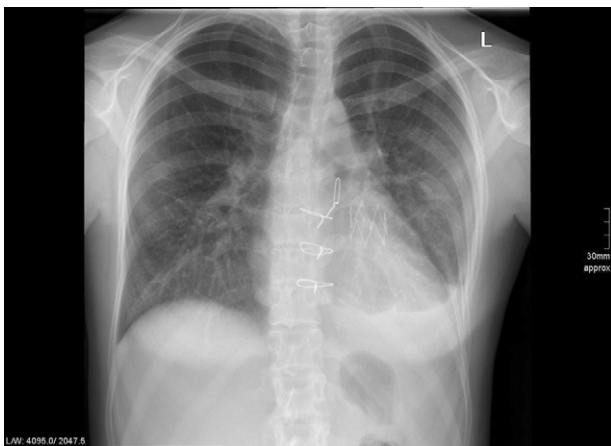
Postoperative chest X-ray showing the valve in the RVOT. The procedure was performed in an adult presenting a repaired TOF with lower mini-sternotomy.
